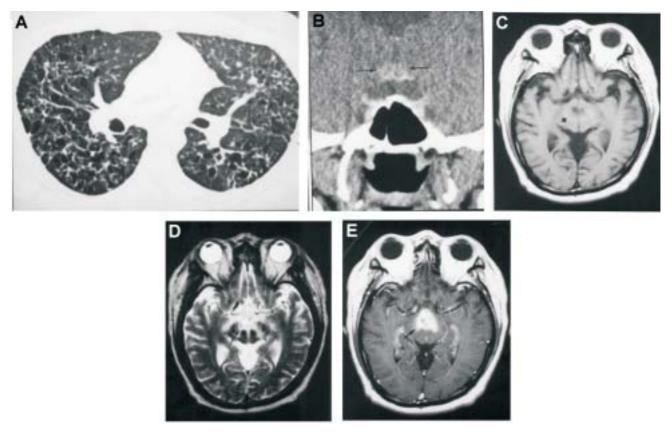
A 37-year-old male non-smoker, diagnosed as Langerhans cell granulomatosis. He had typical pulmonary HRCT images and diabetes insipidus. (A) HRCT of lung through the subcarinal level shows multiple cystic lesions in both lungs and thickened interlobular septa. (B) Contrast enhanced coronal CT of brain discloses abnormal enhancement in the suprasellar region (arrows). (C, D, E) MRI reveals an infiltrating hypothalamus mass (arrow) with mixed signal on T1WI (TR/TE = 550/10/ axial), hyper-intense on T2WI (TR/TE/450/25/axial) and contrast enhancement on T1WI (TR/TE/450/25/axial).
